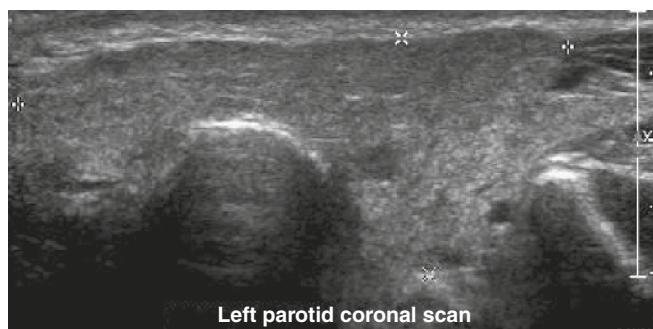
Transverse ultrasound image shows the normal anatomy of the left parotid gland.
